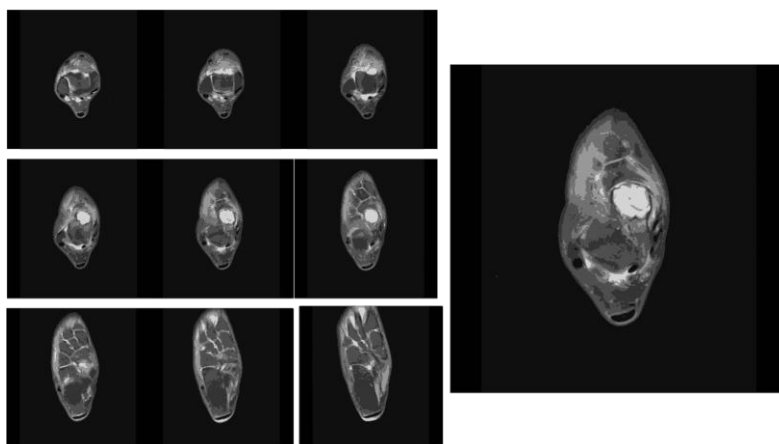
Right Ankle MRI T2W Axial View.
